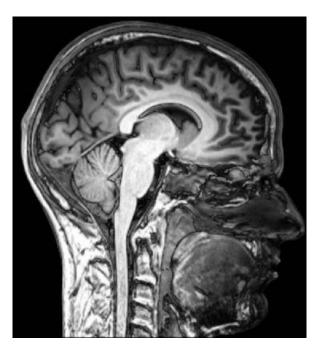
Magnetic Resonance Image Scan [2]
